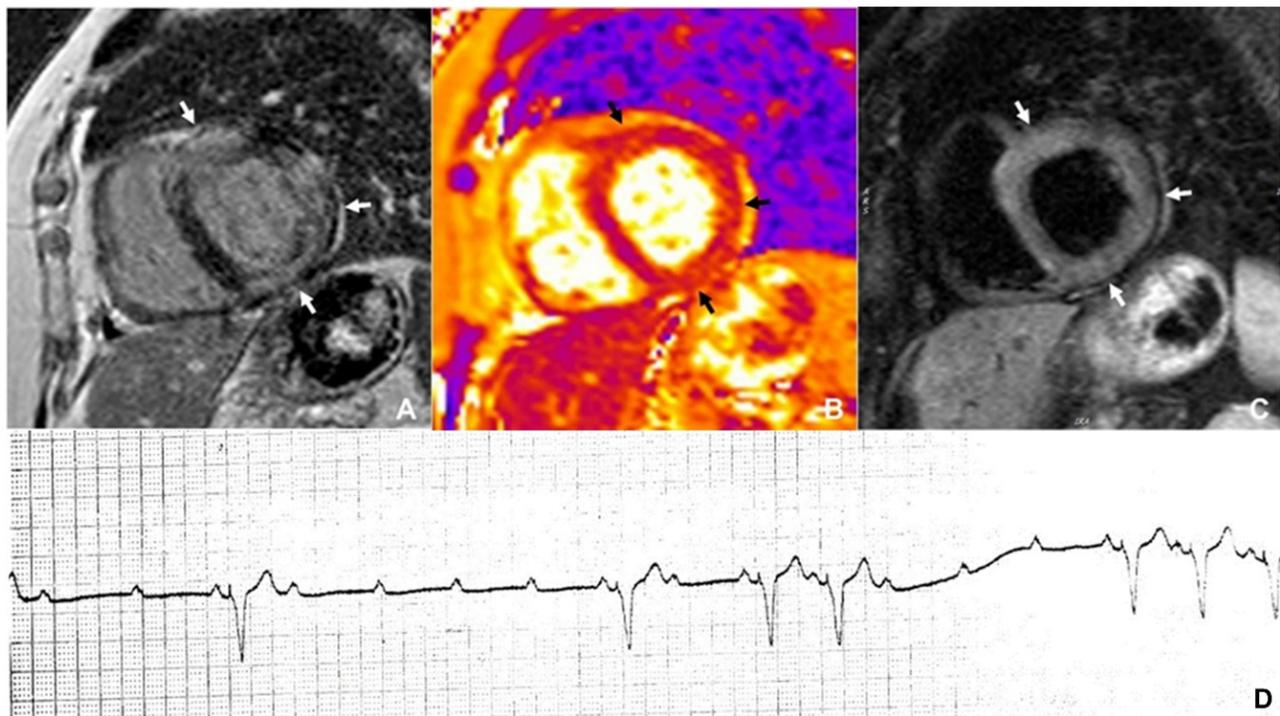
CMR imaging in a patient with cardiac sarcoidosis. Large patches of mid-wall late gadolinium enhancement in the anterior, inferolateral and inferior left ventricular walls (white arrows) (A) in a patient with cardiac sarcoidosis and episodes of complete heart block (D). Co-localized myocardial edema seen as brighter areas on T2-mapping (B; black arrows) and T2-weighted images (C; white arrows). CMR, cardiac magnetic resonance.
